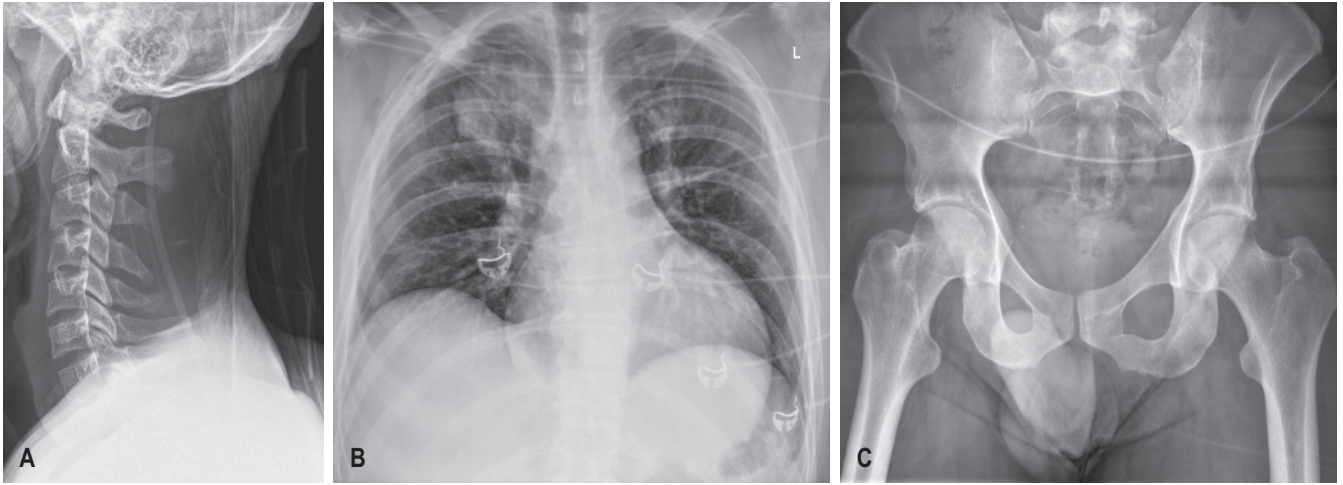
(A) Normal lateral cervical radiograph from a trauma series. (B) Chest x-ray from a trauma series with right-upper-zone pulmonary contusion. (C) Normal pelvic x-ray from a trauma series.
